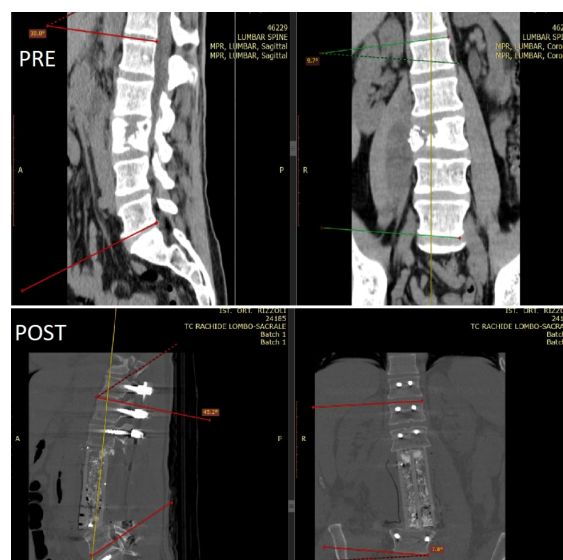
CT images cobb angle pre and post surgery with titanium 3D custom made
